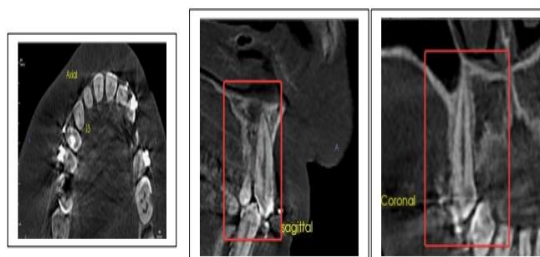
a,b,c Cone beam computed tomography images of maxillary right arch obtained for the study subjects are shown in three-dimensional, axial, coronal, and sagittal views
